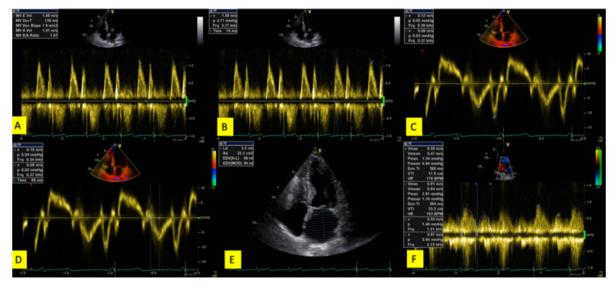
Different echocardiographic parameters used for evaluation of left ventricular diastolic dysfunction A. The sample volume of pulse wave Doppler was placed in the tip of the mitral leaflets and blood velocity in early diastole (E) and late diastole (A) and deceleration time of E velocity to baseline (msec) were measured.
